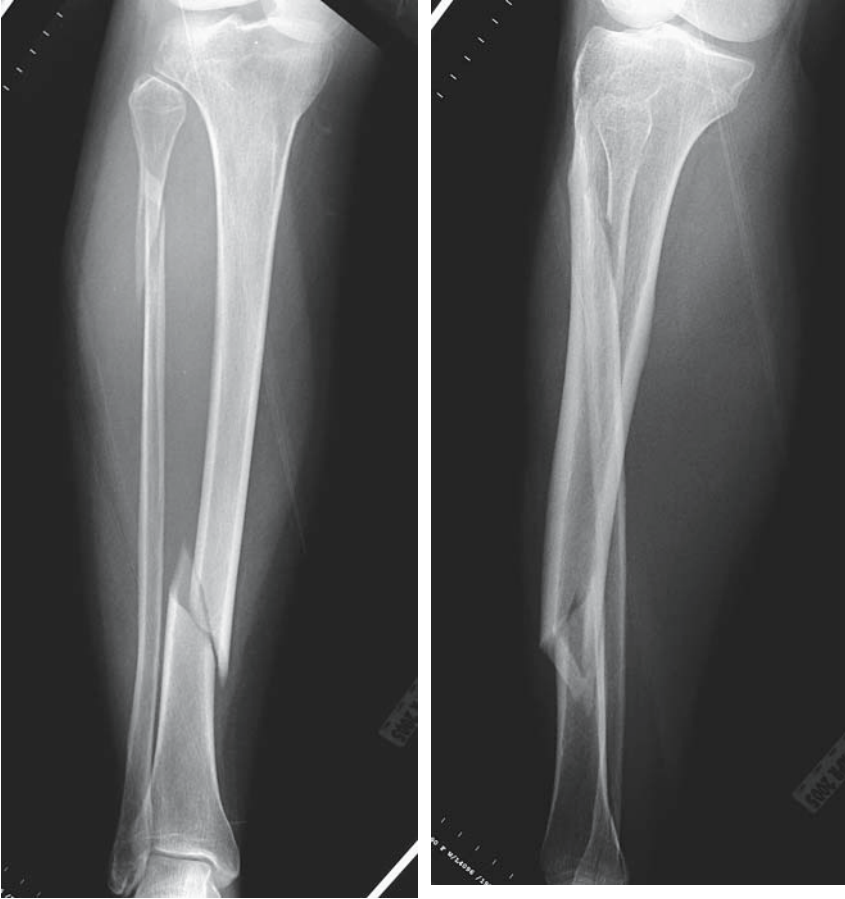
Preoperative radiographs show spiral tibia fracture with proximal fibular fracture.
